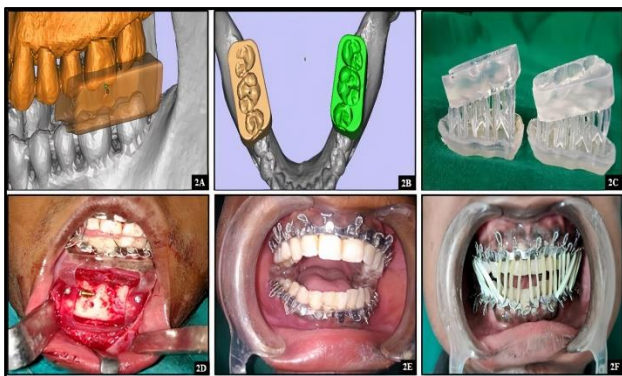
(A) Virtual planning for the specific shape of customized hypomochlion splint on a maxillomandibular model by analyzing surface data of the occlusal surface of the posterior teeth. (B) 3D computed tomography showing virtual design of the splint on the left and right posterior segment. (C) Customized 3D printed hypomochlion splint fabricated using biocompatible resin with vertical dimension of 3mm and 1mm respectively. (D) Intraoperative ORIF of left parasymphysis fracture using lag screw.
